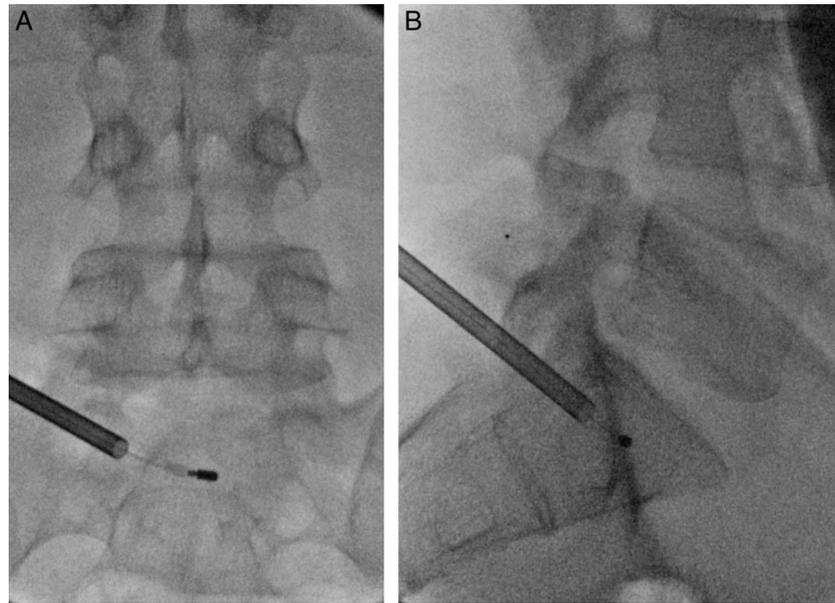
A, AP x-ray demonstrating final midline position of the electrode at S1. B, Lateral x-ray with final position of the electrode between 50% from the anterior and posterior vertebral body and 40% from the superior endplate.
